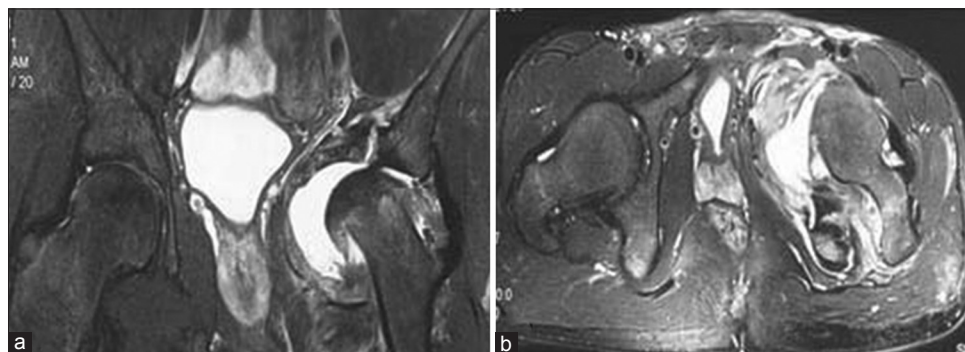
Coronal (a) and axial (b) sections of magnetic resonance imaging of pelvis showing expansive lytic lesion of acetabulum and pubic rami with soft tissue involvement and joint effusion
